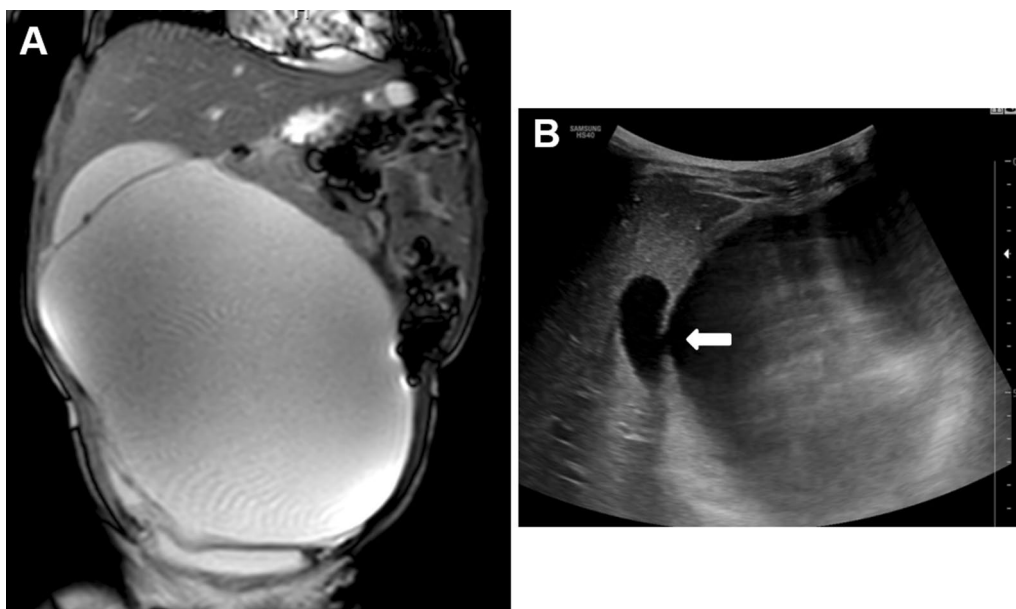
A 2-year-old boy with ventriculo-gallbladder shunt presented with increasing abdominal girth. A Coronal abdomino-pelvic T2 SPIR and B corresponding ultrasound show a large abdomino-pelvic loculated fluid (CSF pseudocyst) with gallbladder mural defect (arrow) demonstrated in ultrasound image
